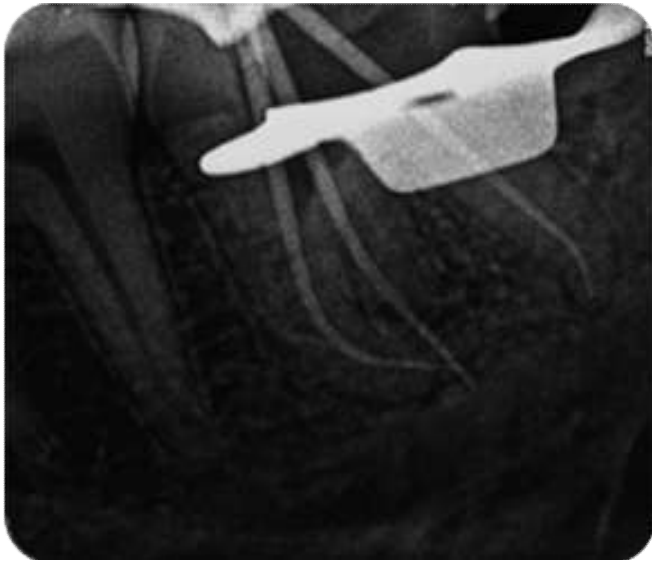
Master cone radiograph
